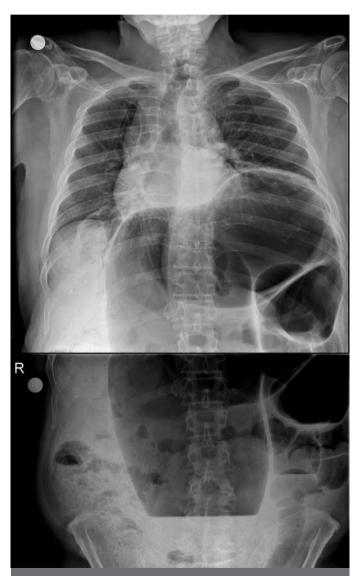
Volvulus and typical "coffee bean" sign in the X-ray
